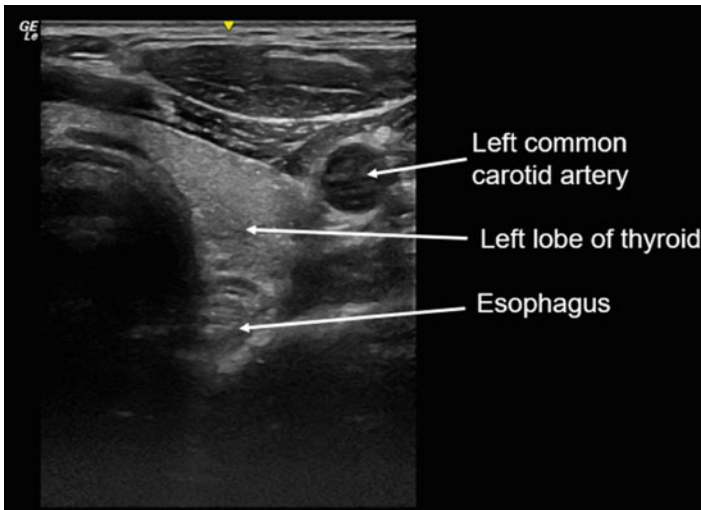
Ultrasound image to locate the esophagus. Note the esophagus is the round target-like structure posterior to the left lobe of the thyroid gland
